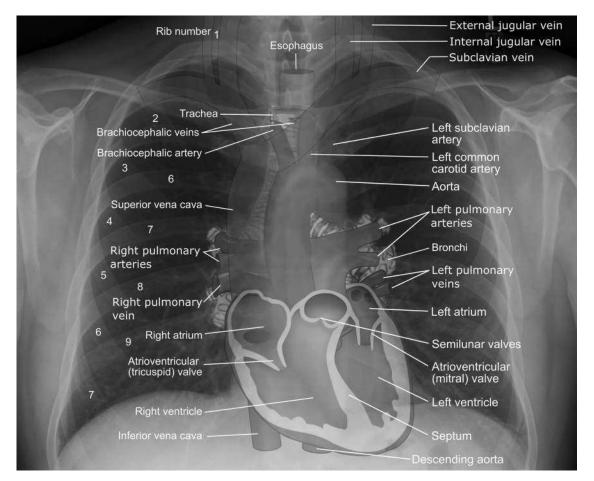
Normal radiograph of the chest. Superimposed on this image are outlines of some of the major topographical landmarks of the chest.
